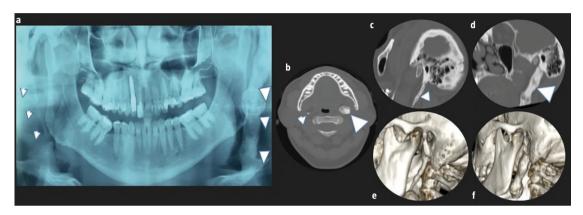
Panoramic pain radiograph showing enlarged styloid processes (arrowheads), with coarse appearance and pseudoarthrosis on the left (a). Computed tomography in axial (b) and oblique sagittal planes (c and d) and 3D volume rendering reconstructions (e and f). Enlarged styloid processes (arrowheads), with coarse appearance and pseudoarthrosis on the left.
